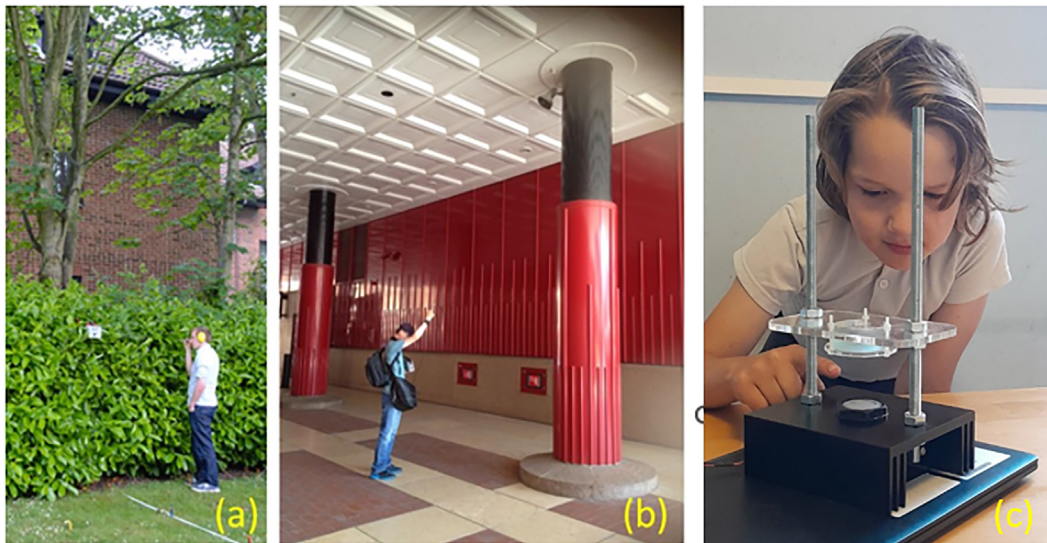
(Color online) Example sources from a wide frequency range. (a) A bird deterrent, which can emit a wide range of frequencies (e.g., 16–40 kHz) depending on the setting, and (b) the output of ceiling-mounted PAVA speakers being measured is shown. These generally emit in the 18–25 kHz range. (c) An ultrasonic device is used to levitate microparticles, which operates around 20 kHz.
